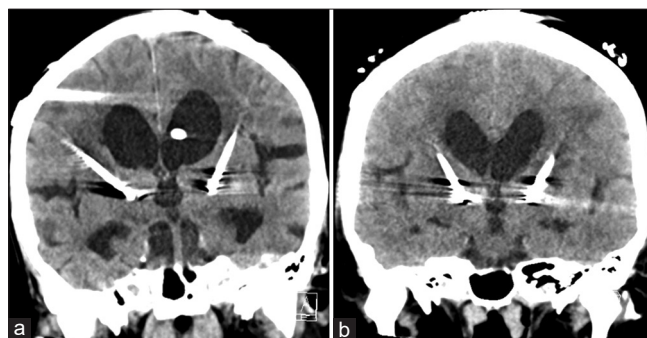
Postoperative coronal computed tomography in (a) patient 1 and (b) patient 2 shows the position of the electrodes at the ventralis intermedia in relation to the ventricles. In (a) patient 1, the presence of a ventriculoperitoneal shunt is additionally demonstrated, implanted using the Keen's point approach.
